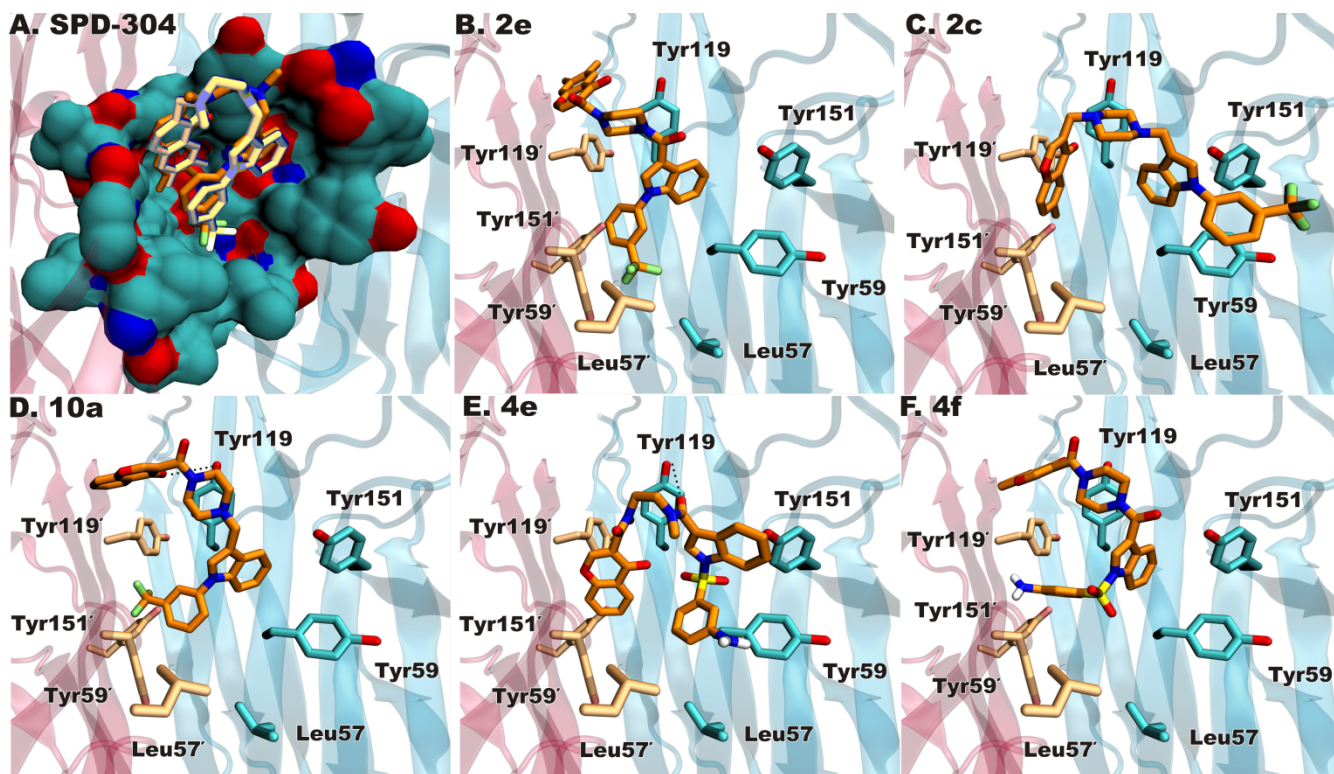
Predicted conformations of the most active compounds in comparison with SPD-304 shown at exactly the same orientation. (A) Surface representation of the SPD-304 binding pocket with the x-ray (yellow carbon atoms) and the best-matched (orange carbon atoms) conformations of the inhibitor. Predicted conformations of the most active compounds 2e (B), 2c (C), 10a (D), 4e (E), and 4f (F) showing the major interacting residues of the SPD-304 binding site that are colored with bright orange or cyan carbons for each TNF monomer, respectively. All other atoms are colored with blue for nitrogen, red for oxygen and green for fluorine.
